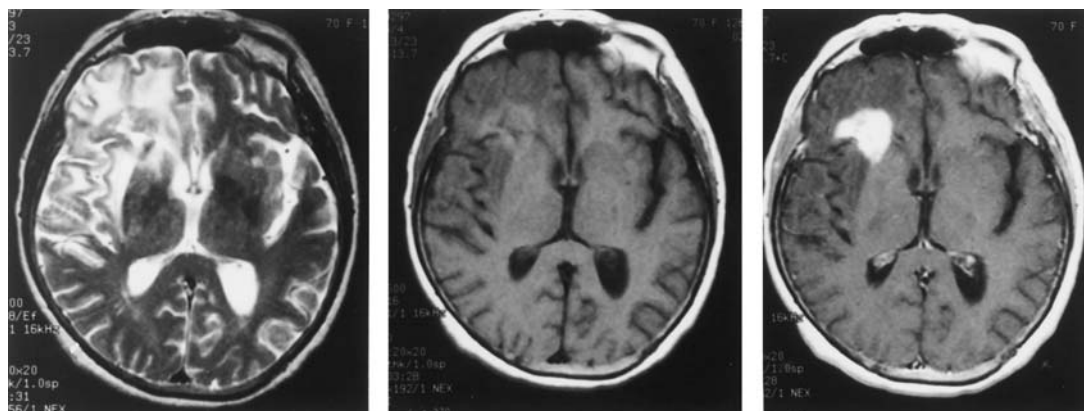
Axial T2-weighted images (left) and T1-weighted images without (center) and with (right) gadolinium enhancement in an immunocompetent patient with primary CNS lymphoma. The right frontal mass appears heterogeneously isointense and hyperintense on T2-weighted images, with surrounding hyperintense edema. On T1-weighted images, the isointense mass enhances densely and homogeneously, following contrast administration.
